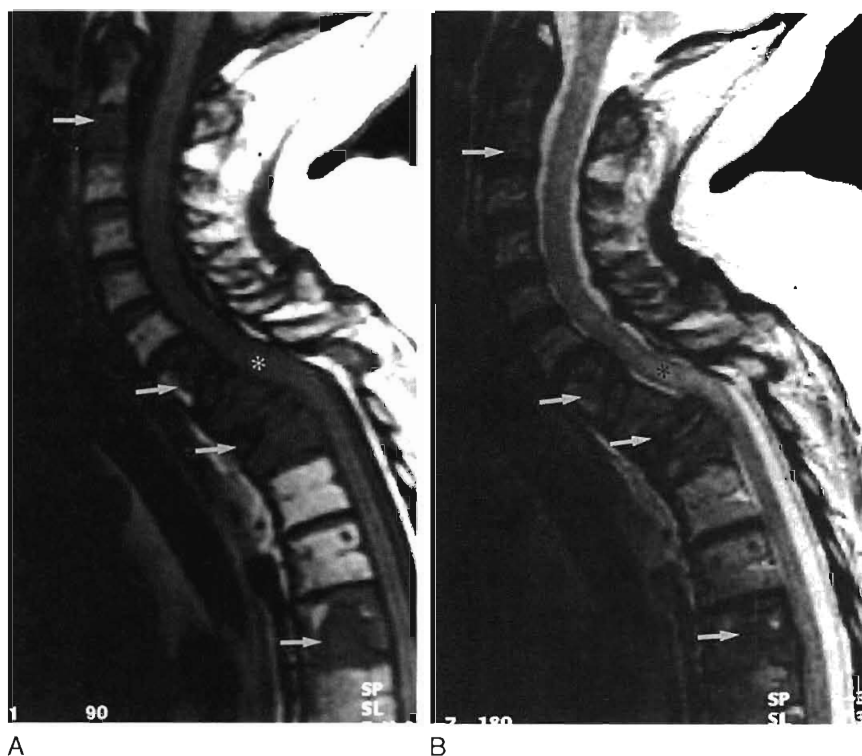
Discitis with epidural abscess. Sagittal post-contrast T1-weighted (*A*) and T2-weighted (*B*) MRI scans demonstrate features of discitis and adjacent osteomyelitis. The vertebral bodies and disc space are of low signal intensity on the T1-weighted image and bright signal intensity on the T2-weighted image (*straight arrows*). An epidural abscess surrounding and compressing the cord is also identified (*curved arrow*).
